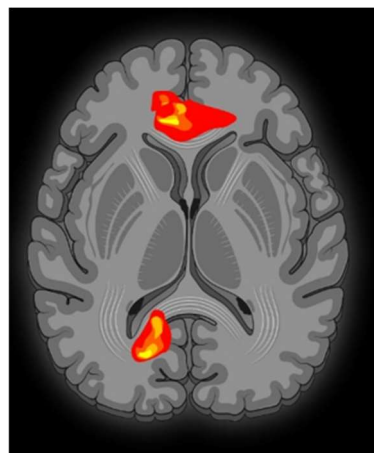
Activation pattern during music listening task. The transversal MRI sequence shows the overall cerebral activation pattern. The lower part of the image will be further explained in Figure 2, while the upper part will be specifically described in Figure 3.
